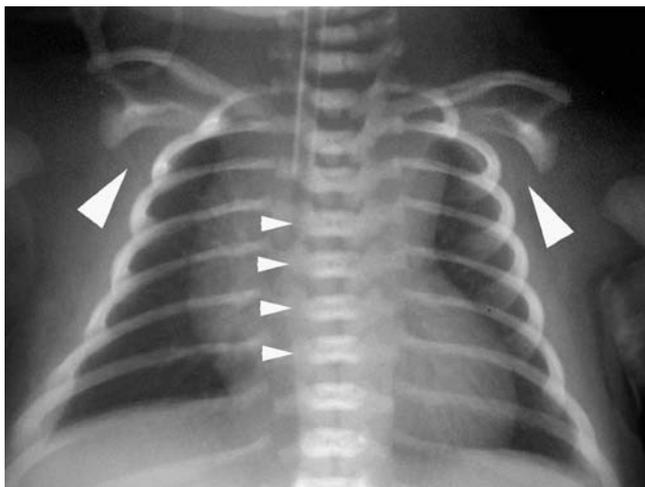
AP radiograph of a newborn with campomelic dysplasia. Of note is the absence of vertebral pedicles in the thoracic spine (present in the lumbar spine) and 11 pairs of ribs. A nearly diagnostic and uniform feature is the hypoplastic scapulae (large arrowhead). Not seen here but often present are cervical kyphosis and cervical or thoracic scoliosis.
